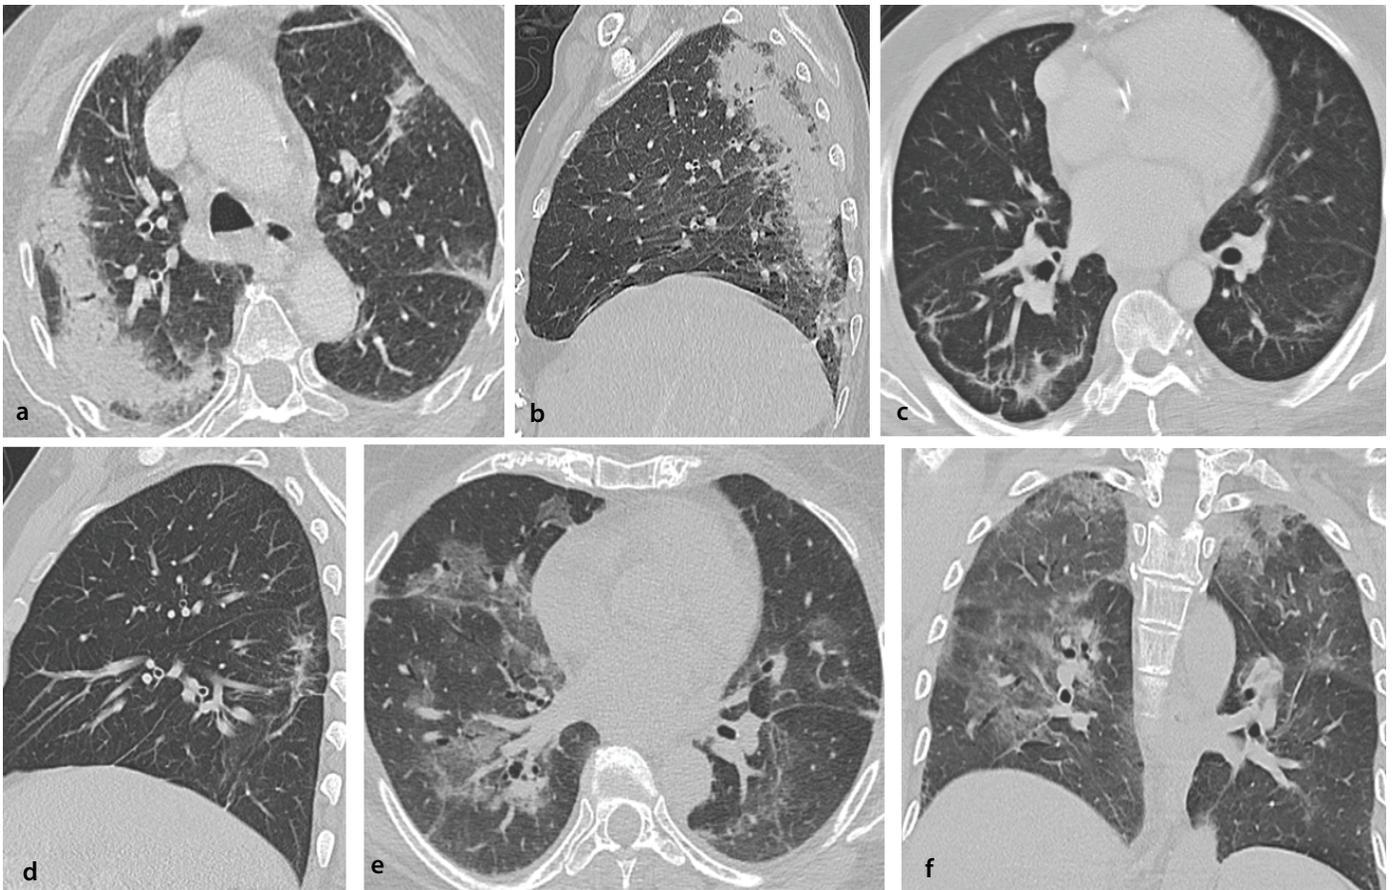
Organizing pneumonia patterns on chest computed tomography (CT). Axial (a) and sagittal (b) CT images demonstrate patchy peripheral consolidations, more prominent on the right side and involving both upper and lower lobes. Axial (c) and sagittal (d) images show peripheral, arcade-like opacities with areas of subpleural sparing. Axial (e) and coronal (f) images reveal patchy peripheral and peribronchial ground-glass opacities.
